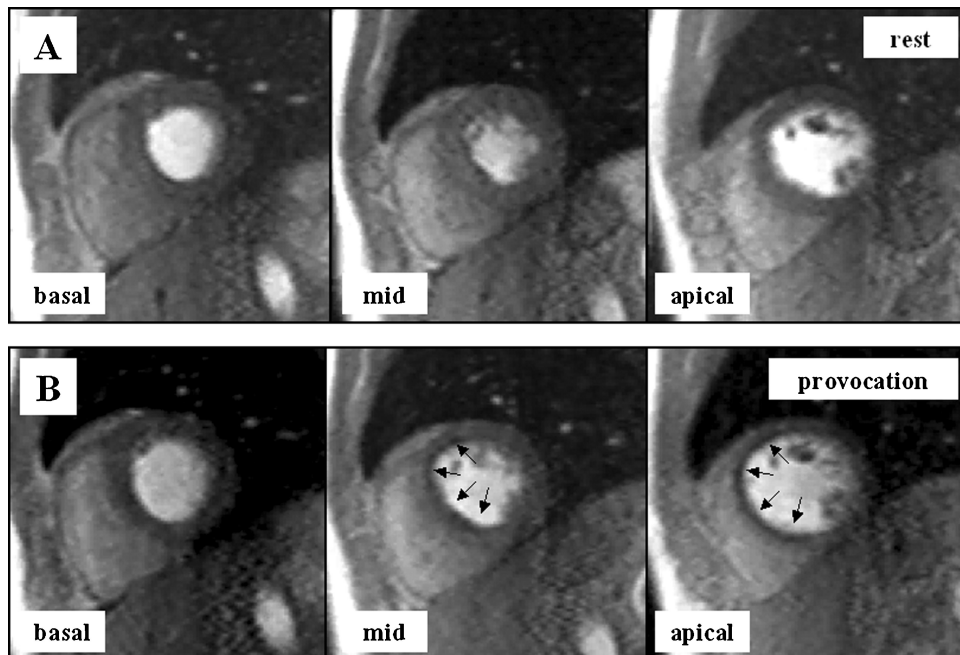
Panel A, Perfusion MRI at rest in three short-axis views (basal, mid and apical) showing no perfusion defect. Panel B, Repeated perfusion MRI after performing a non-invasive spasm provocation with a combination of hyperventilation and cold-pressure-test. An extensive subendocardial perfusion defect in the anterior septal wall (mainly in the mid and apical short-axis) is detectable compared to the resting images.
